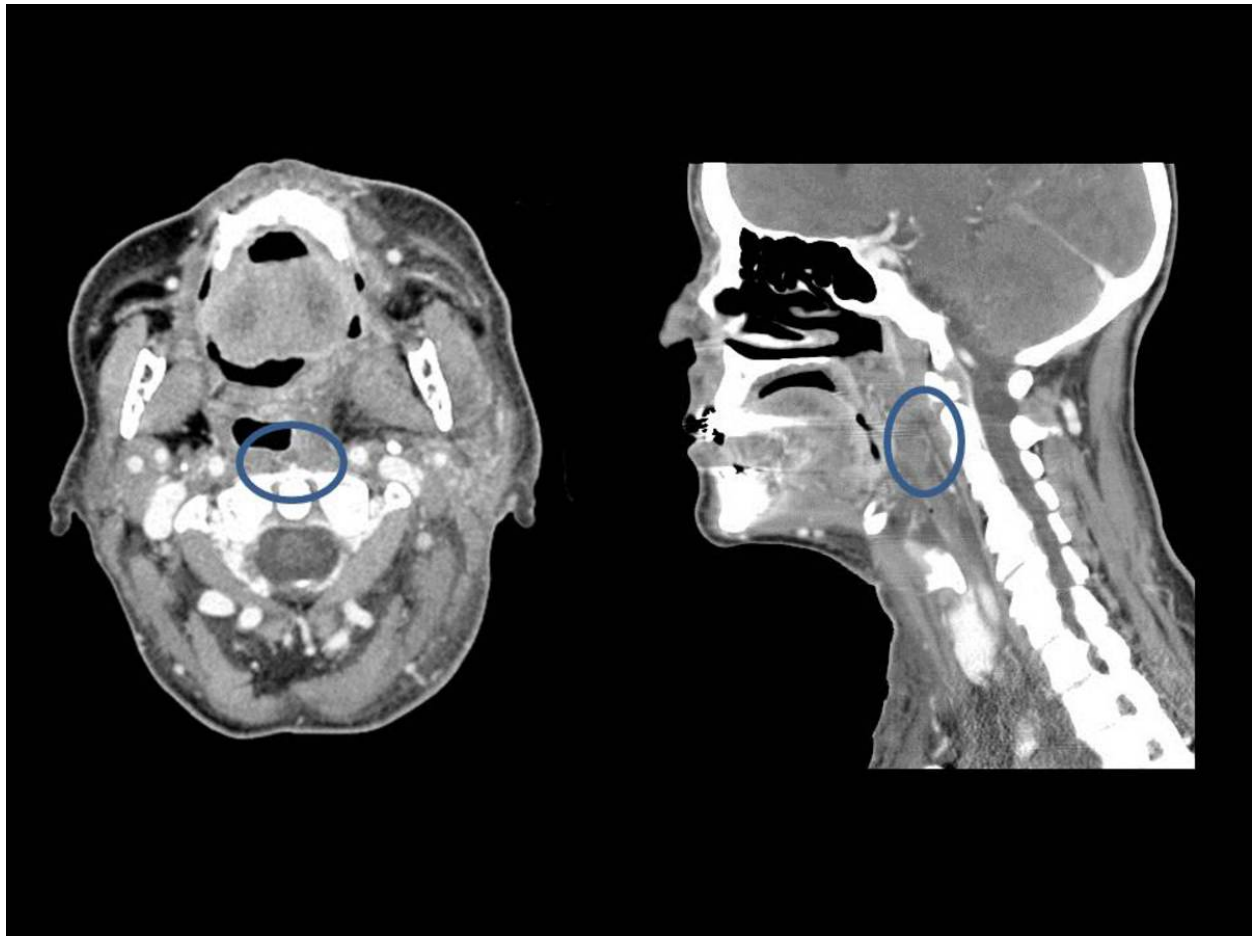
Retrovisceral edema: axial, coronal and sagittal enhanced computed tomography images of a 30 years old man with pharyngitis and an parapharyngeal abscess. Fluid fills the retropharyngeal space from side to side, has a rectangular configuration and tapered inferior and superior margins, with no mass effect or wall enhancement.
